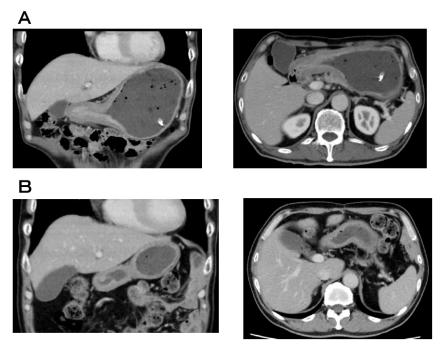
Computed tomography findings of Case 9.
